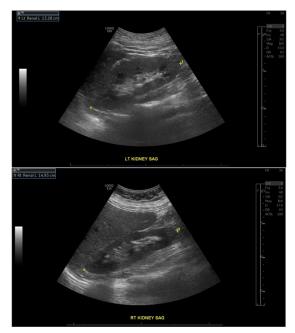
Bilateral renal enlargement on renal ultrasound with the left kidney measuring 13.28cm and the right kidney measuring 14.93cm.
